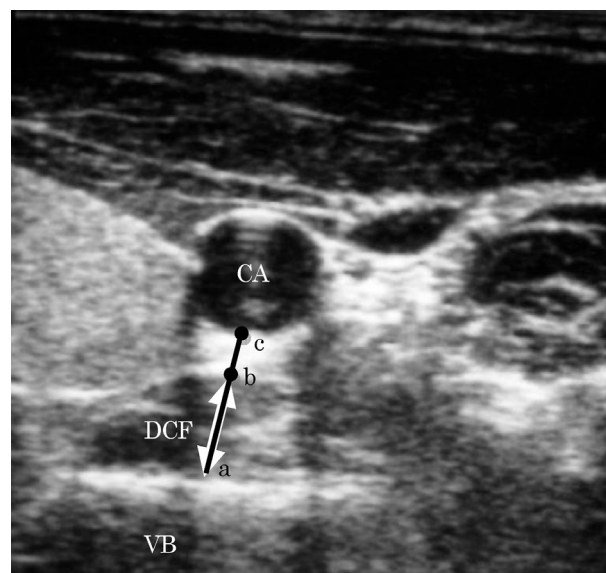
Ultrasound imaging of the deep cervical flexor muscles (DCF). The diagonal dimension of the DCF (ab) was measured as the distance between the anterolateral boundary (muscular fasciae of the DCF) and posteromedial boundary (the vertebral body) (VB) in the line that passes through the nearest 2 points between the carotid artery (CA) (c) and the muscular fasciae of the DCF (b).
